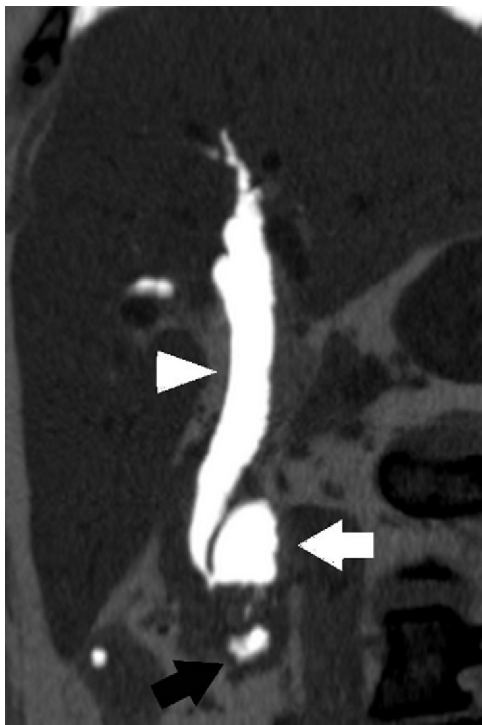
Multidetector computed tomography; oblique multiplanar reconstruction at minimum intensity projection showing air in the common bile duct (white arrowhead), juxtapaillary duodenal diverticulum (white arrow) and horizontal portion of the duodenum (black arrow).
